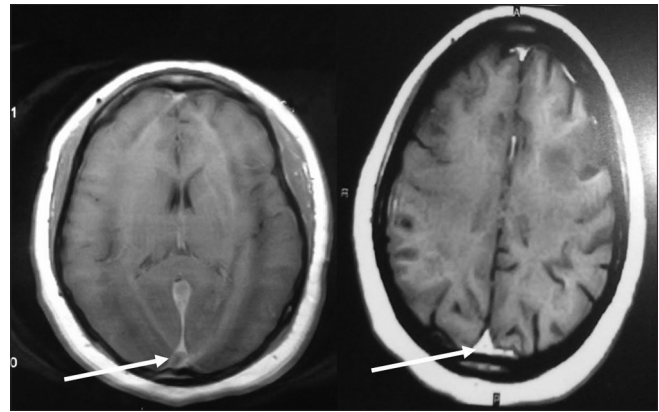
T1-weighted magnetic resonance imaging showing a hyperintense signal from the thrombosed sagittal sinus
